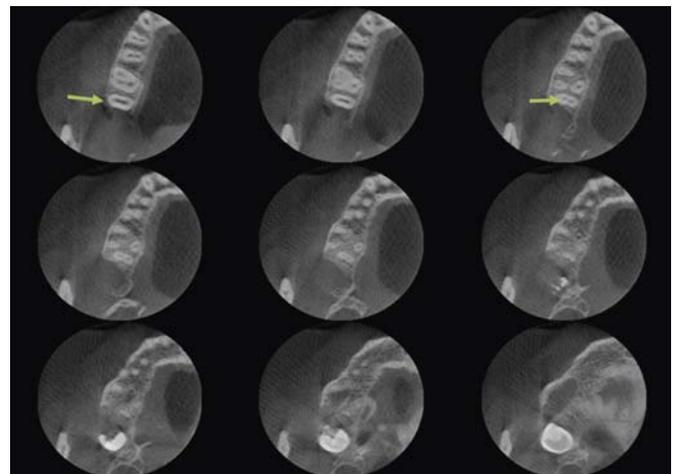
CBCT image (axial section—right side)
